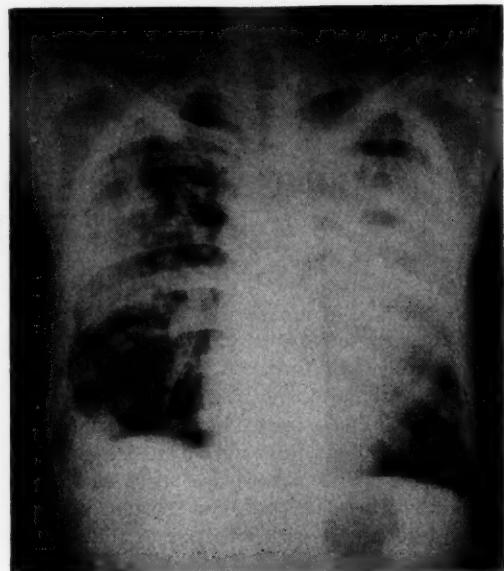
Admission x-ray of first patient described in text.
